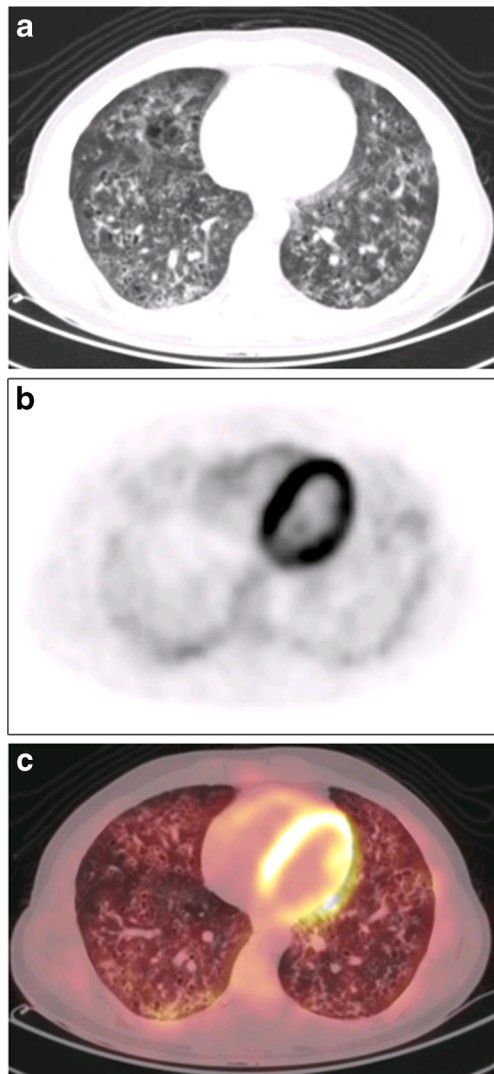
Patient #12. a CT part of PET-CT examination showing thick-walled lung cysts; b PET image showing moderate but significant uptake (SUVmax = 3.4) in these cysts; c corresponding fused PET-CT image
